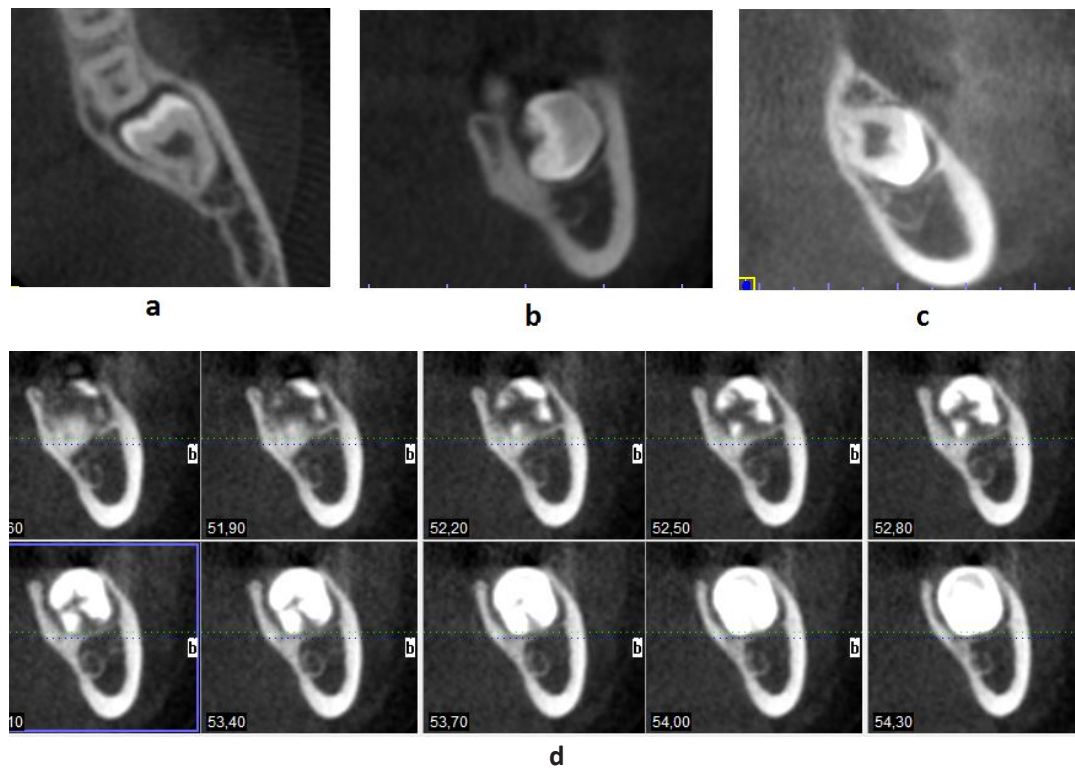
CBCT cross-sectional images of impacted maxillary third molar; a: coronal section, b: sagittal section, c: axial section, d: view in vertical sections.
